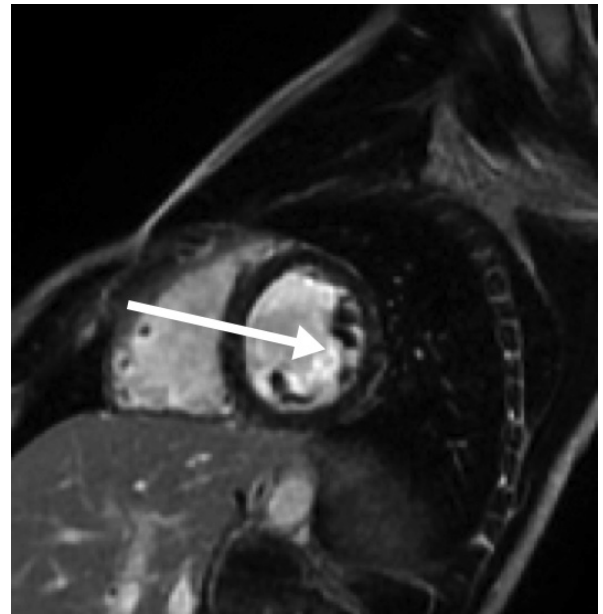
Magnetic resonance imaging of the heart. Reduced LVEF and RVEF. The images of late enhancement after contrast administration show spotted areas of pathological enhancement of the myocardium in the subepicardium in the lateral wall of the left ventricle, at the level of the middle segments. Post-inflammatory lesions were identified within the left ventricular lateral wall, with a significantly reduced left ventricular ejection fraction (LVEF = 48%) and in the right ventricle (RVEF = 46%)
